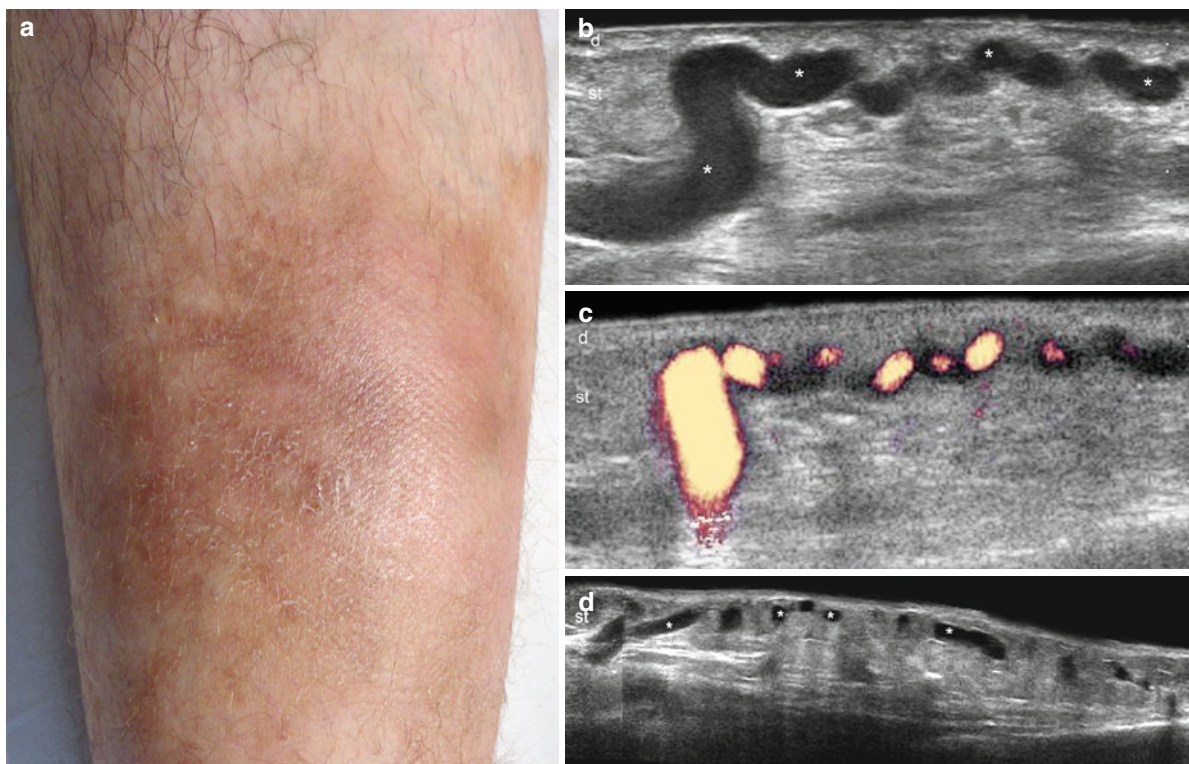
(a–d) Venous insufficiency. (a) Clinical view shows hyperpigmentation and swelling in the anterior aspect of the leg. (b) Gray scale ultrasound image (longitudinal view) demonstrates dilated and tortuous perforans venous vessels (*) affecting mostly the upper subcutaneous tissue. (c) Power Doppler ultrasound image (longitudinal
